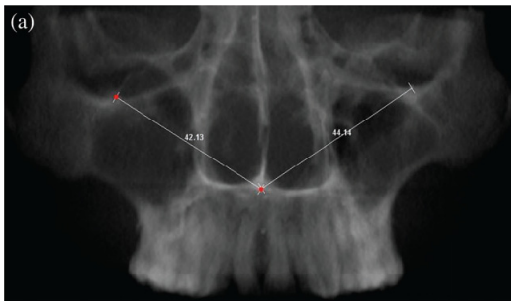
Linear measurements on two-dimensional radiographs. (a) Postero-anterior projection: between OI(R)-ANS and OI(L)-ANS. (b) Lateral cephalogram: between ANS-PNS OI-ANS.
